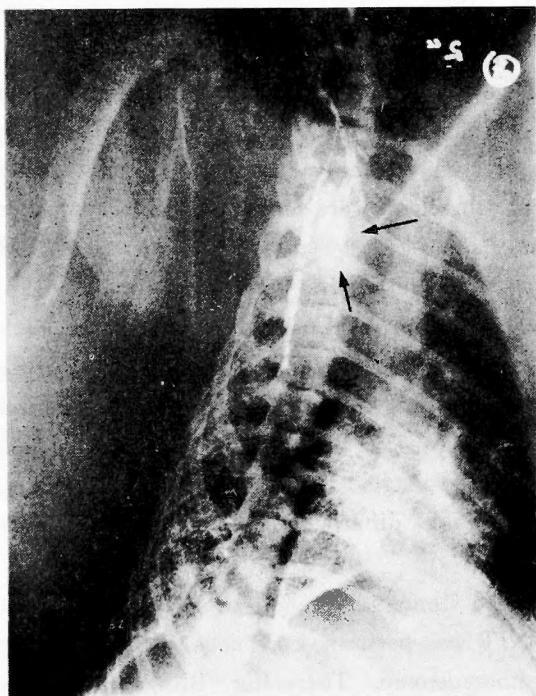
The retrograde lymphangiography of the thoracic duct. The picture shows that the regional lymph nodes in the upper mediastinum are observed on a roentgenogram with the infusion of 5 ml of Lipiodol.
